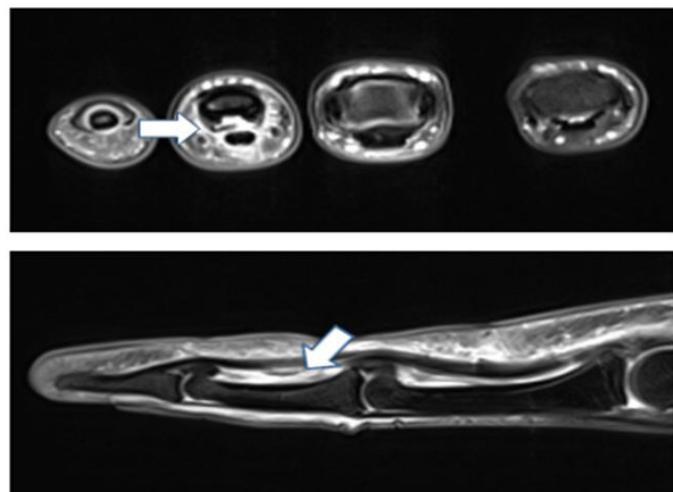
MRI imaging of the torn A4 pulley, displaying pulley entrapment under the deep flexor tendon resulting in increased E-Space.
